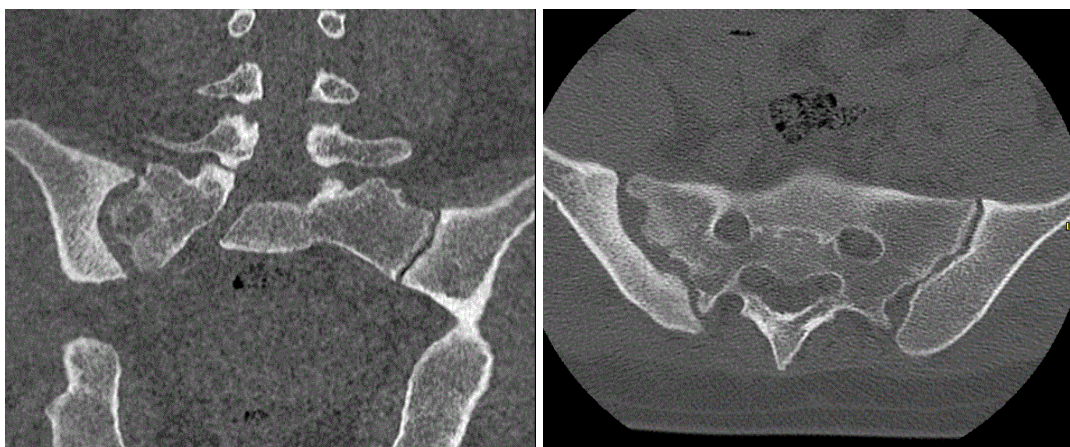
CT scan of the lumbosacral spine in axial and coronal section showing a right sacroiliitis with significant widening of the joint space, erosions and subchondral geodes on the articular side of the sacrum, with bone sequestration
